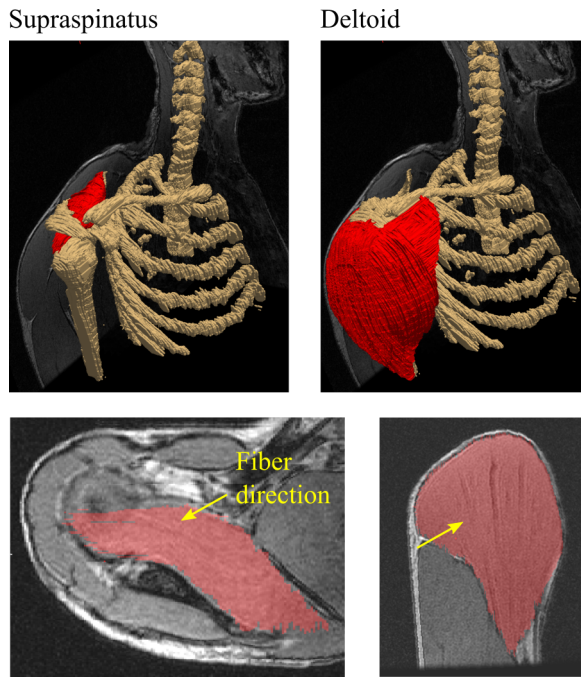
Muscle Volumes and Fiber Directions. High resolution MRI scans allow accurate estimates of muscle volume (top). Cross-sectional slices reveal muscle fiber directions and attachment points for muscles, allowing accurate muscular kinematic modeling (bottom). Two muscle exemplars are shown. The MRI images (below) have a translucent red overlay marking the segmented muscle cross section.
